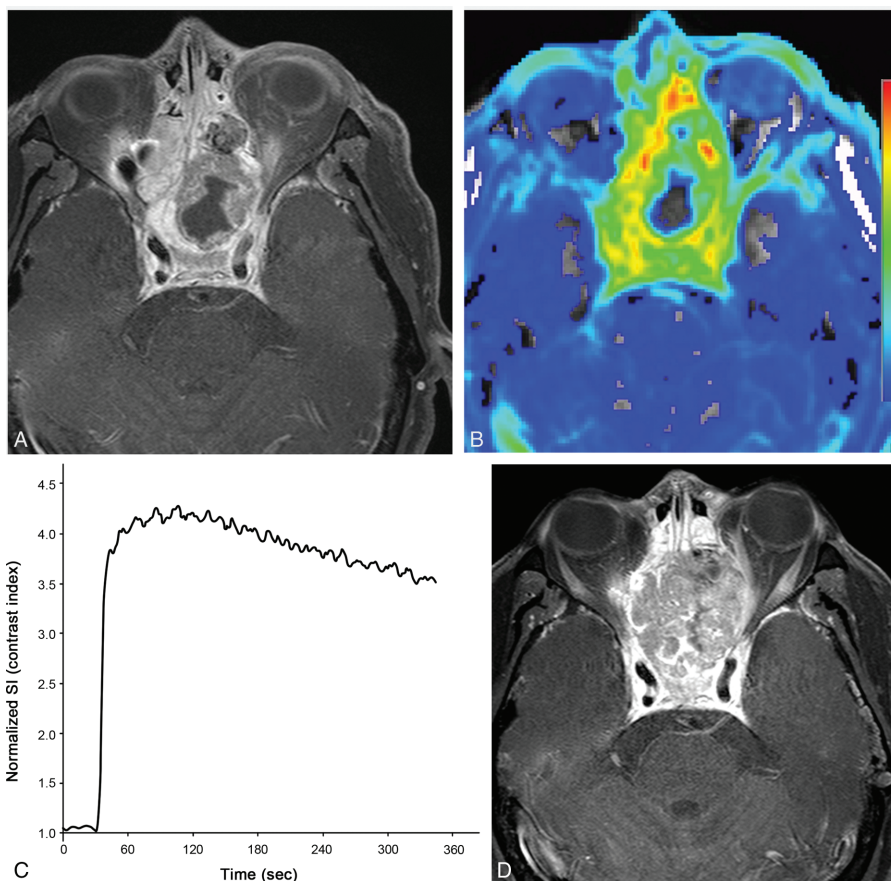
Local recurrence of a nasopharyngeal cancer in a 60-year-old man. (A) Contrast-enhanced T1-weighted MRI showing an expansile mass in the ethmoidal and sphenoidal sinuses after treatment. (B) AUC60 map derived from DCE-MRI analysis showing a relatively fast visual increase in AUC in the corresponding areas of the contrast-enhancing lesion. (C) TSI curve of the entire enhancing lesion showing wash-out (type III) with an AUC60 value of 154.03. (D) 26-week follow-up MRI showing an increase in mass size, thus suggesting local recurrence. AUC = area under the curve, DCE-MRI = dynamic contrast-enhanced magnetic resonance imaging, MRI = magnetic resonance imaging, TSI = time-signal intensity.
